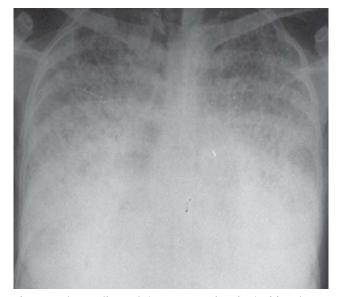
Chest radiograph (postero-anterior view) of fourth case demonstrating a diffuse symmetric, dense, micronodular ('sand-storm') pattern.
